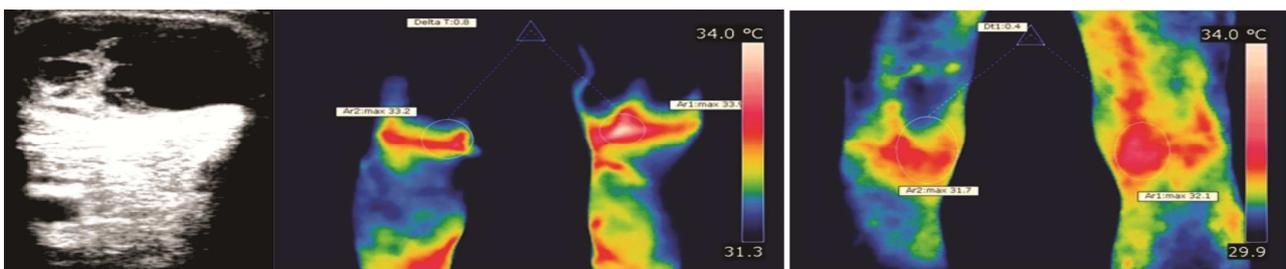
Baker cyst ultrasound and thermography before and after treatment ( $\Delta T$  decrease from 0.8 to  $0.4^{\circ}\text{C}$ )
